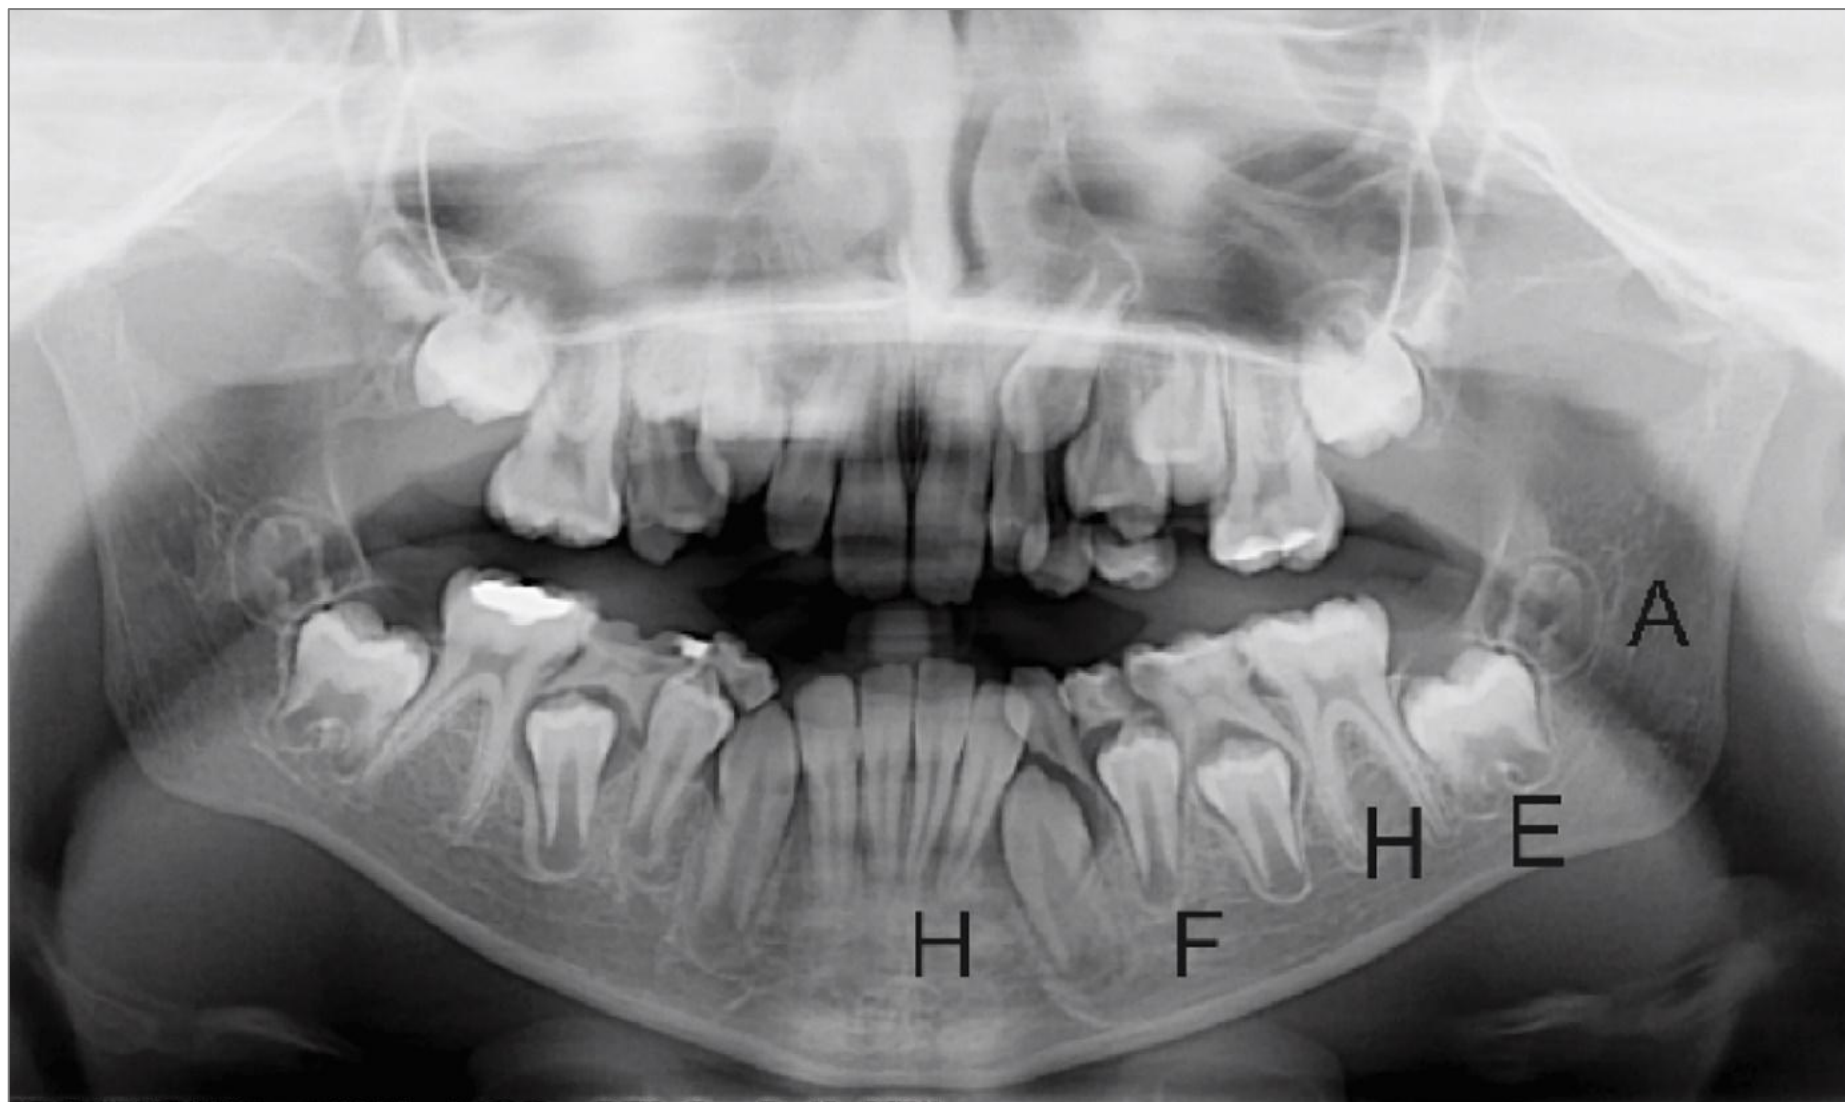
Demonstration of mineralisation A, E, F and H stages on orthopantomography by Demirjian's method
